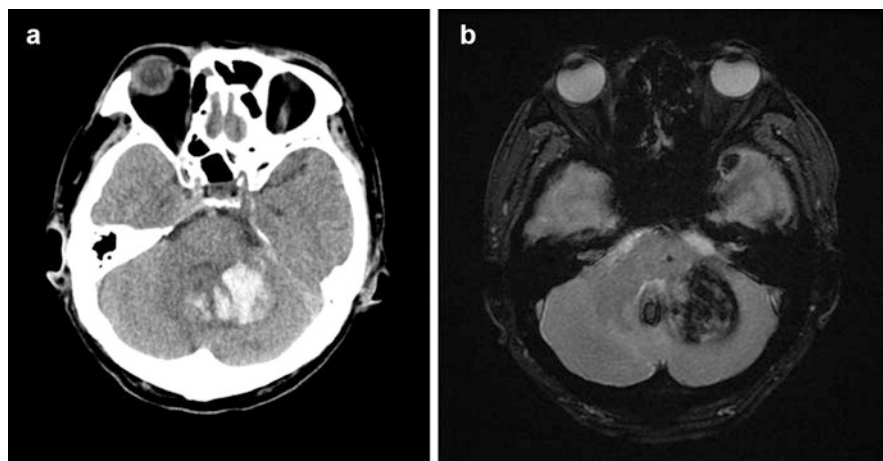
Cerebellar hemorrhage. Brain computed tomography (a) shows hemorrhage in the left cerebellum. This lesion is demonstrated as low signal intensity on T2*-weighted gradient-echo imaging (b)
